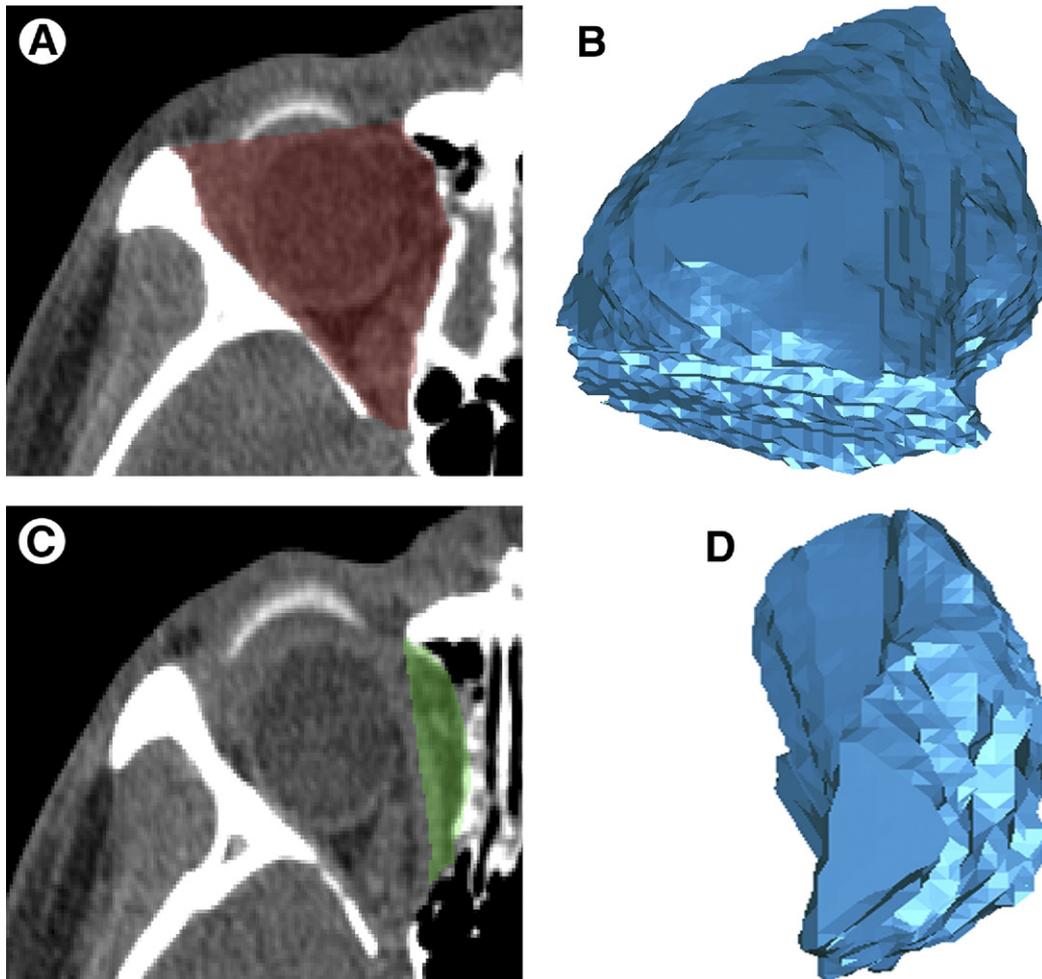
Measurement of the orbital socket. *A*, Outlining the border of the orbital socket in the axial computed tomography scan. The zygomatic bone represents the lateral and the lateral nasal wall the medial border. *B*, Reconstructed 3-dimensional images of the orbital socket are delivered by the Mimics software package. *C*, Outlining the herniated content in the medial border of the orbital socket. *D*, Reconstructed 3-D image of the herniated tissue.
